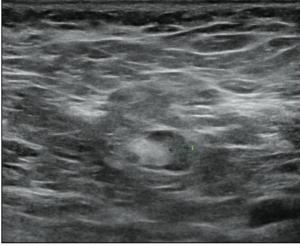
Ultrasound examination. On the left hand side, one of the 2 enlarged lymph nodes in the left axilla, measuring 9 mm in the short axis with normal fatty hilum with perinodal fat swelling with increased echogenicity in-keeping with Kikuchi Fujimoto disease. On the right hand side a normal looking lymph node in the right axilla
